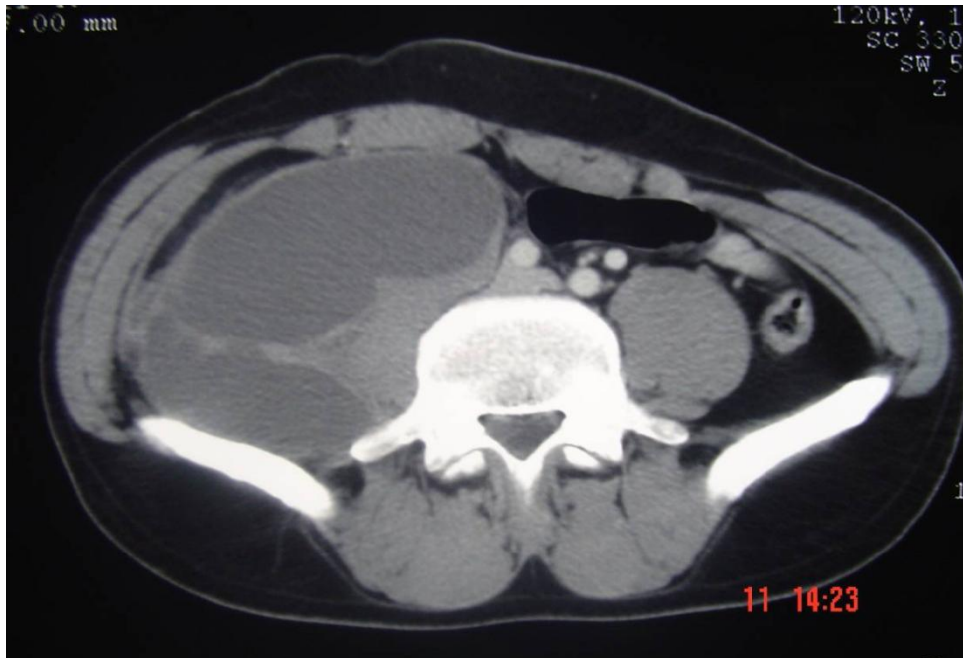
CT scan image shows a large hydatid cyst developing on the right iliac psoas muscle.
